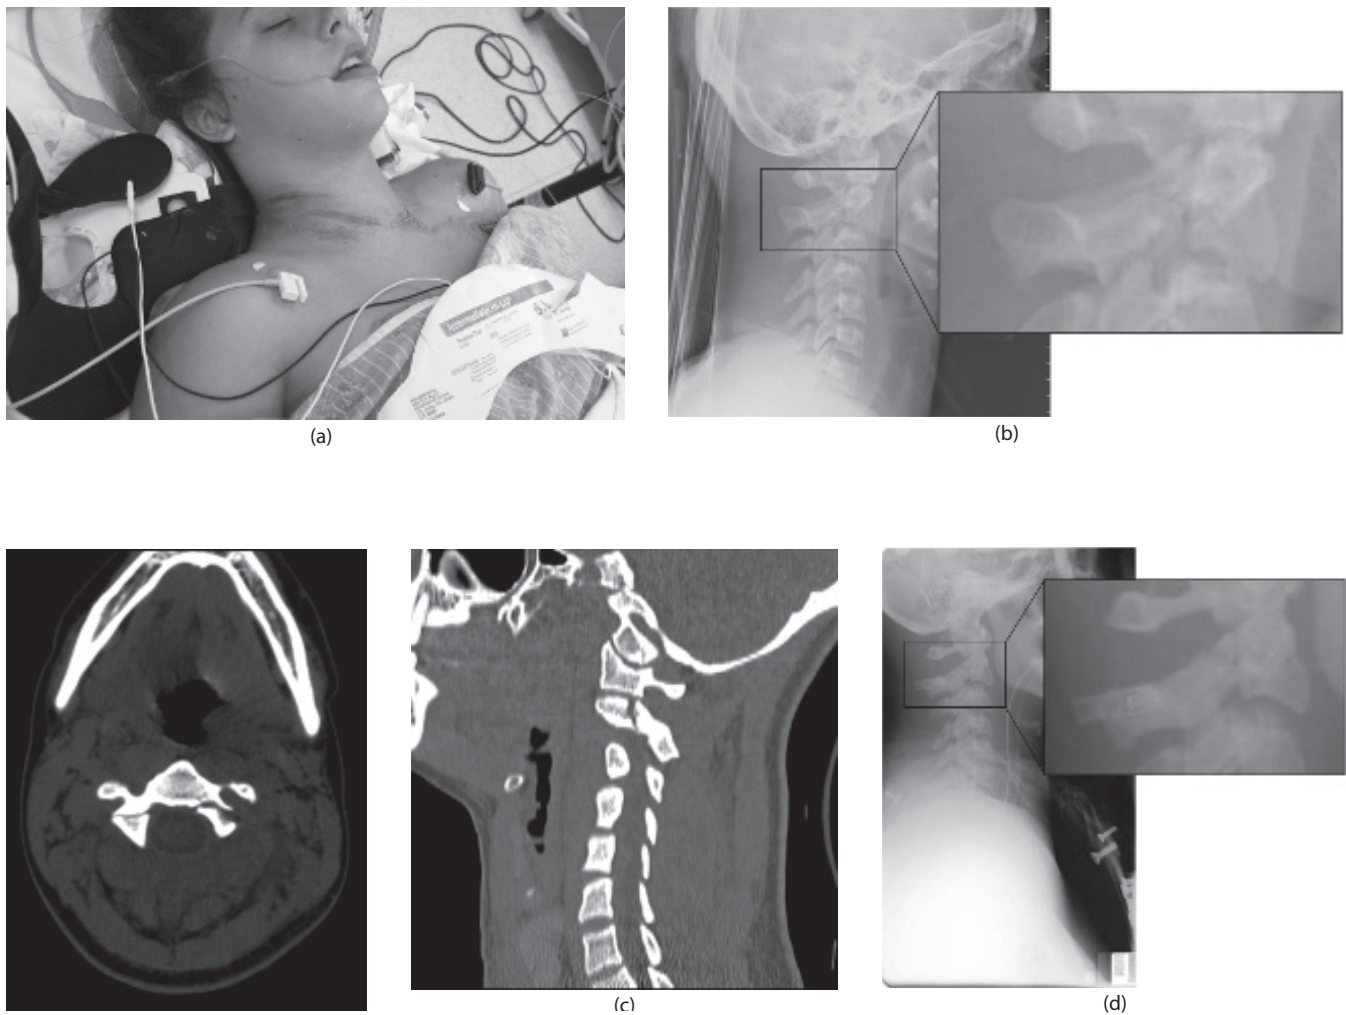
Example of a patient with a hangman's fracture. (a) Clinical image. (b) Injury x-rays. (c) Injury CT scan. (d) X-ray after closed reduction and halo application. (Courtesy of Dr. John P. Dormans, Texas Children's Hospital.)
